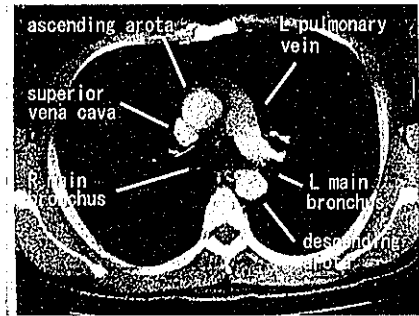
Autopsy imaging, CT, slice #13, control
